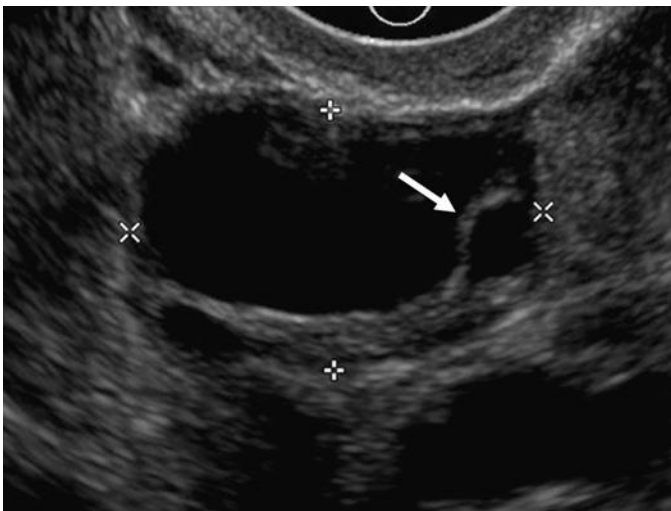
Dominant follicle. Transvaginal longitudinal sonogram of the right ovary (*calipers*) shows a dominant anechoic follicle with a peripheral ring representing the cumulus oophorus (*arrow*).
